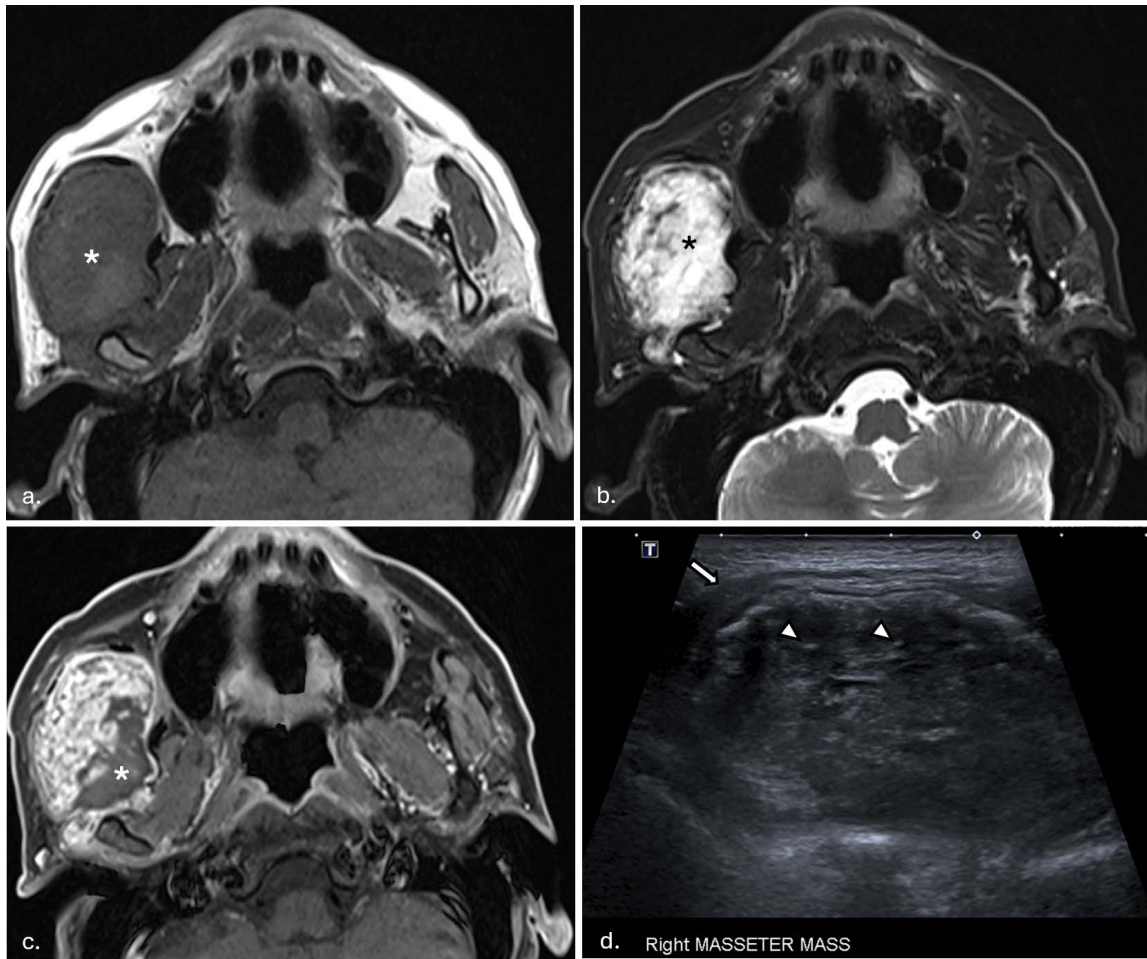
1.5T MRI and sonographic appearances of the mass; Unenhanced axial T1w image (a) [TR 680ms TE 12ms] shows a right masticator space mass (*) which is isointense to muscle; Axial fat-saturated T2w image (b) [TR 4190ms TE 79ms] shows marked T2w-hyperintensity of the mass (*) and the close relation between the posterior aspect of the mass with the temporomandibular joint capsule; Contrast-enhanced axial T1w fat suppressed (c) [TR 680ms TE 12ms] images show heterogeneous enhancement within the mass with areas of non-enhancement (*); images obtained during ultrasound-guided biopsy of the mass (d) show a hypoechoic mass with peripheral and internal (arrowheads) calcifications deep to the masseter muscle (arrow).
